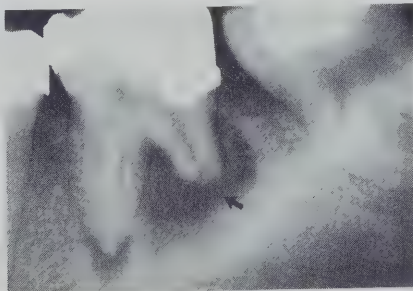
(Case 11). Reproduction of X-ray film showing obvious periapical bone destruction (arrow).
